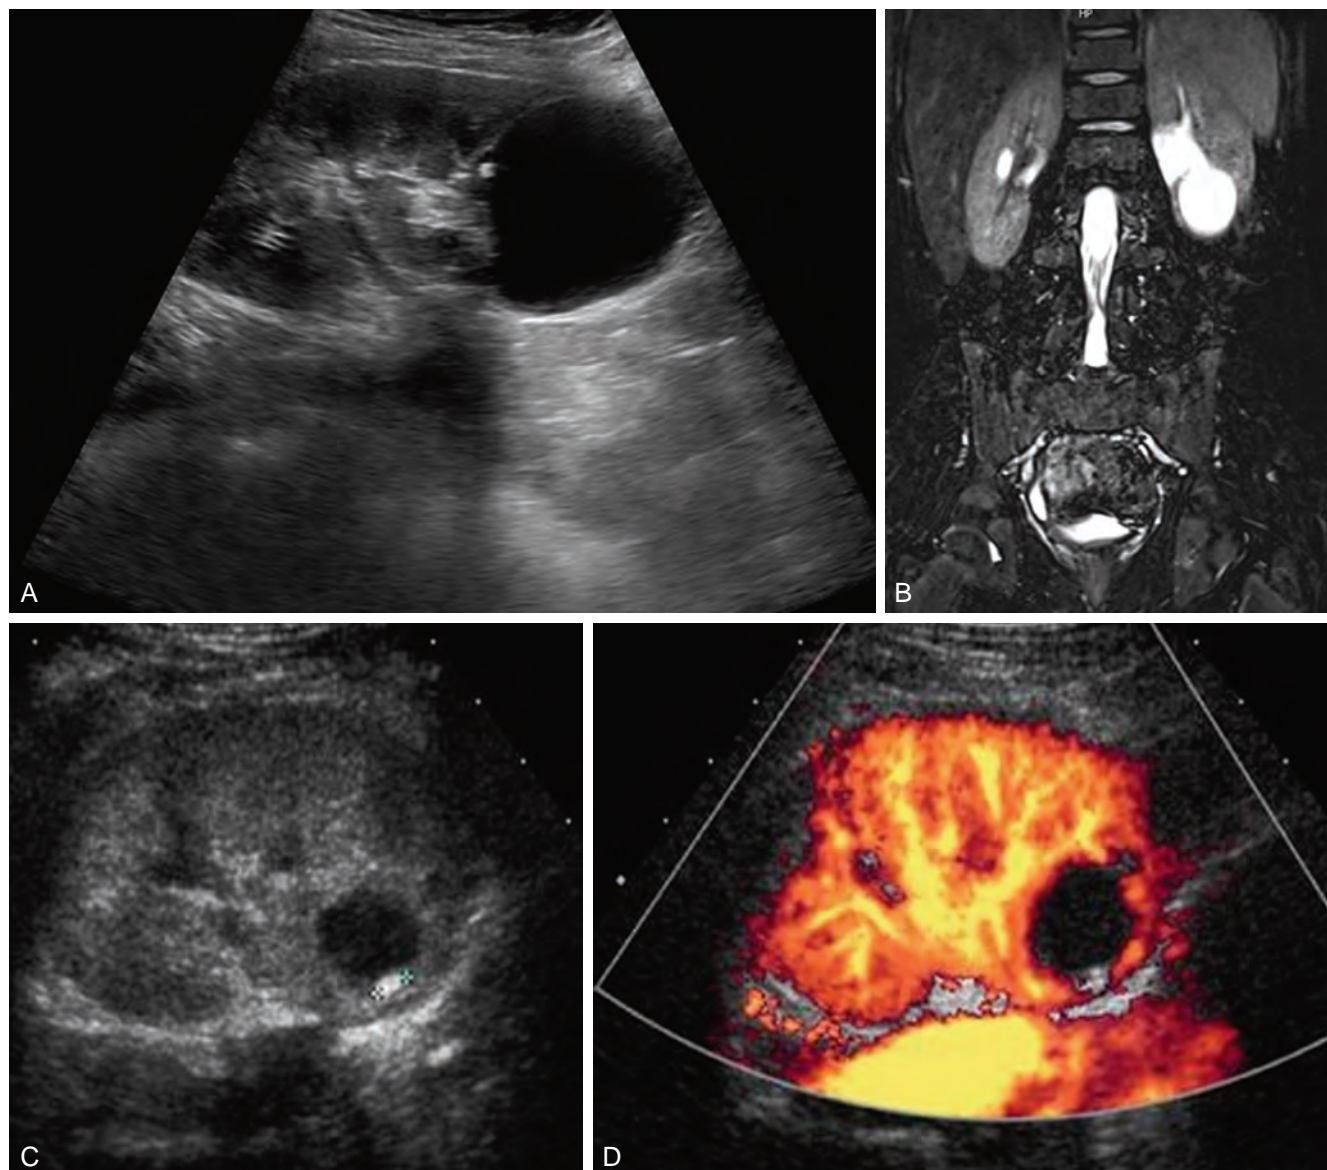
Lower pole calyceal diverticulum. A, Sagittal sonogram. B, Sequence of coronal T2 images. C, Sagittal sonogram shows small stone within a diverticulum. D, Color Doppler sonogram demonstrates absence of flow. (B, Courtesy Dr. Sara Milla.)
